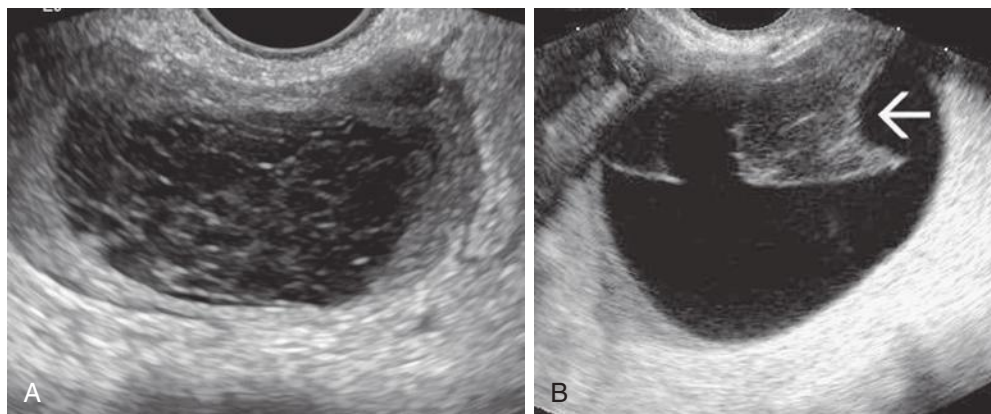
Hemorrhagic ovarian cysts. A, This hemorrhagic cyst has a “fishnet” or reticular lace-like pattern of internal echoes due to fibrin strands. Fibrin strands typically appear as thin linear or curvilinear echoes that do not extend across the span of the cyst but appear discontinuous. True internal septations usually course from wall to wall across the cyst. B, A hemorrhagic cyst from another patient has a solid-appearing area with a concave margin (arrow) due to retractile clot. Color Doppler imaging (not shown) demonstrated no flow in the clot.
